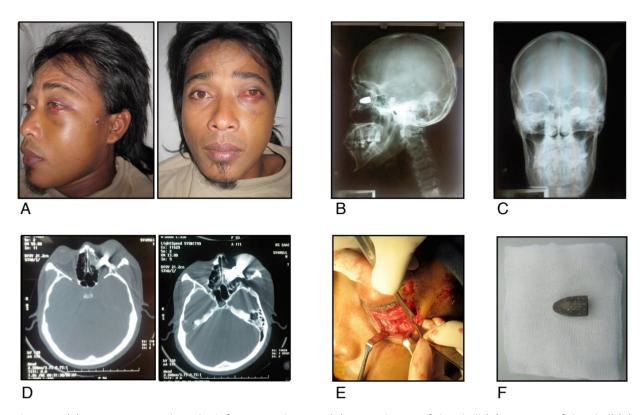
(a) Entrance wound on the left temporal region (A), Lateral view of the skull (B), AP view of the skull (C), Axial section of CT image showing the bullet (D), infraciliary insicion was made to expose infraorbital region (E), the bullet after being extracted from the inferior rectus orbital muscle (F).
